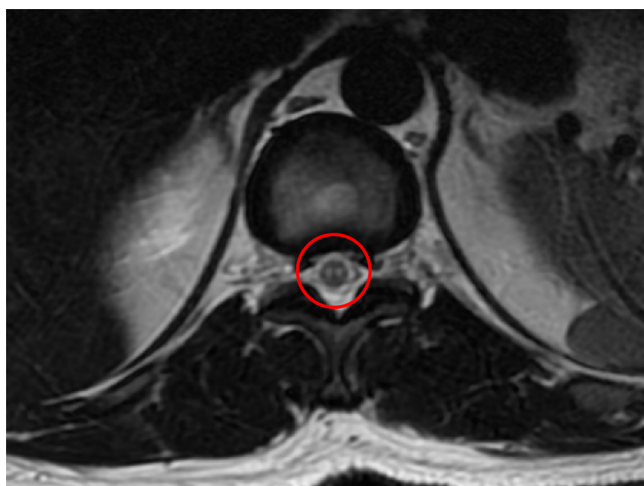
Nuclear magnetic resonance imaging. Intramedullary alteration at the level of medullar conus, suggesting an acute–subacute ischemia.
